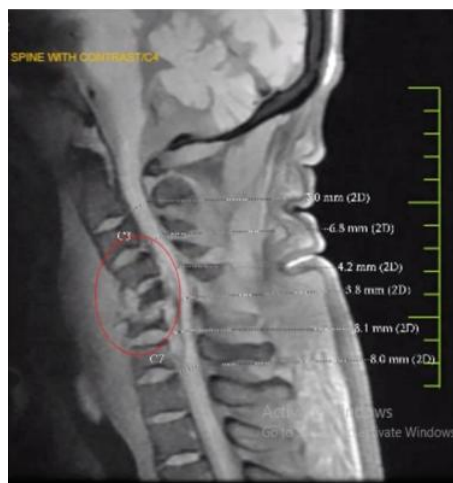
Patient 2-MRI spine showing cervical C5-C6 epidural abscess, vertebral osteomyelitis
